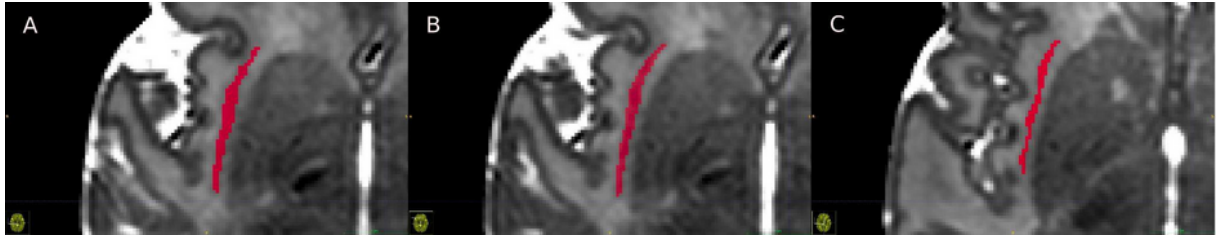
Axial MRI slices with manual claustrum segmentation.
